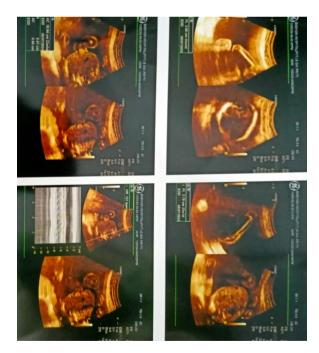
Ultrasonogram of the uterus showing monochorionic, monoamniotic twin pregnancy with a single face, single thorax and abdomen with separate upper and lower limbs.
